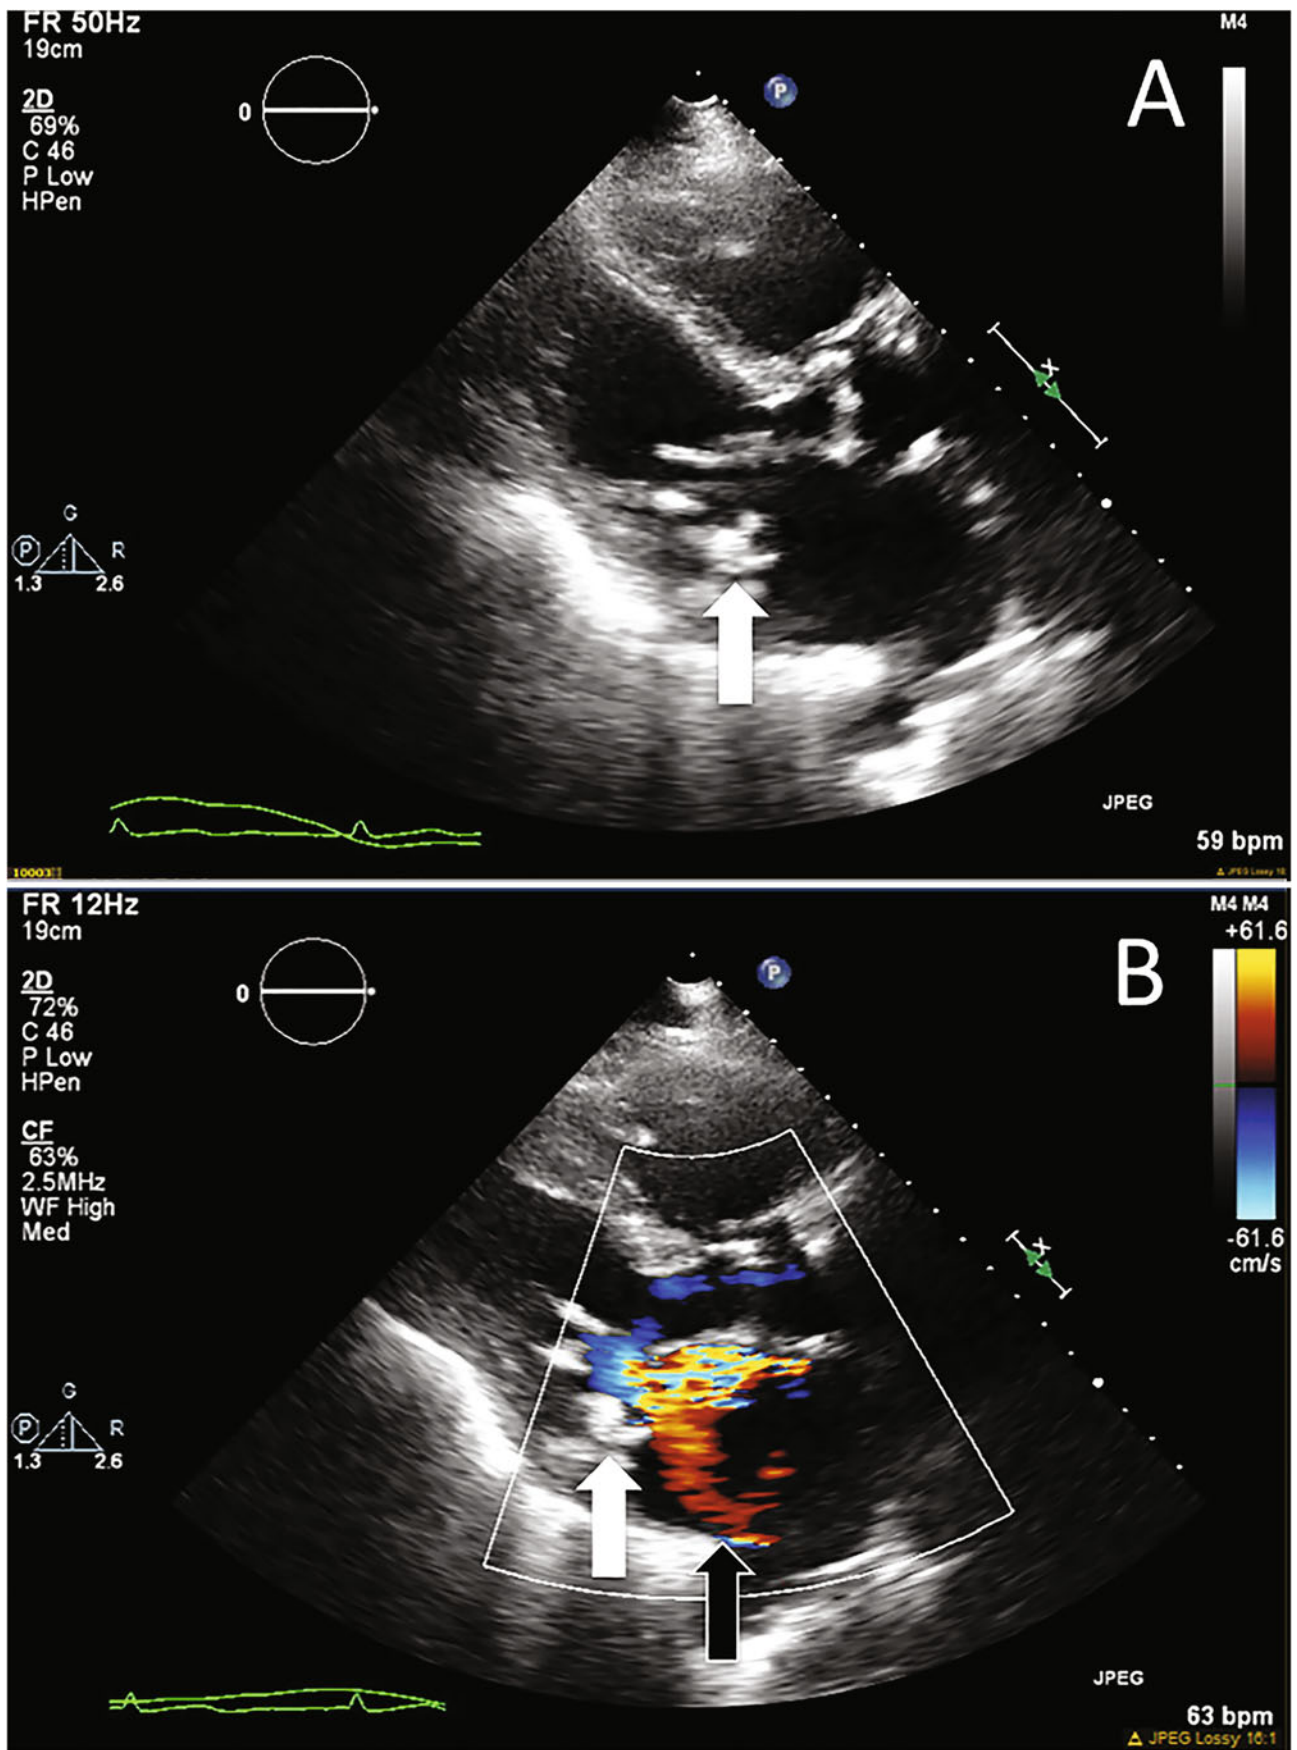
Transthoracic echocardiogram (TTE) revealing posterior mitral annular calcification (MAC, white arrows a, b) causing restriction of the posterior mitral leaflet with the resulting severe mitral regurgitation on Doppler (b, black arrow)
